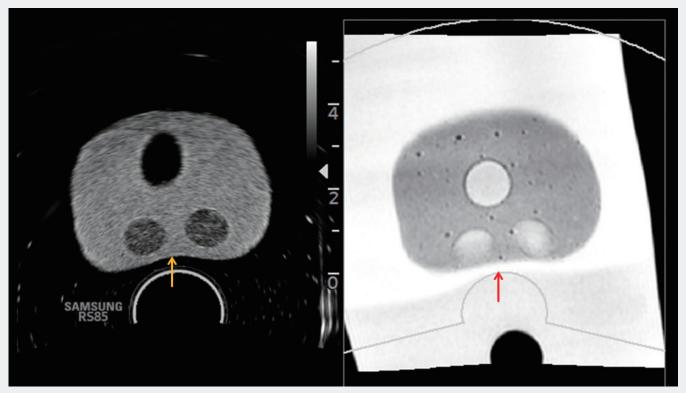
The deformation correction algorithm on the system could be used to improve the accuracy of registration by correcting deformed prostate MRI shape (red arrow) when transducer is compressed the tissue (yellow arrow) during the procedure.
